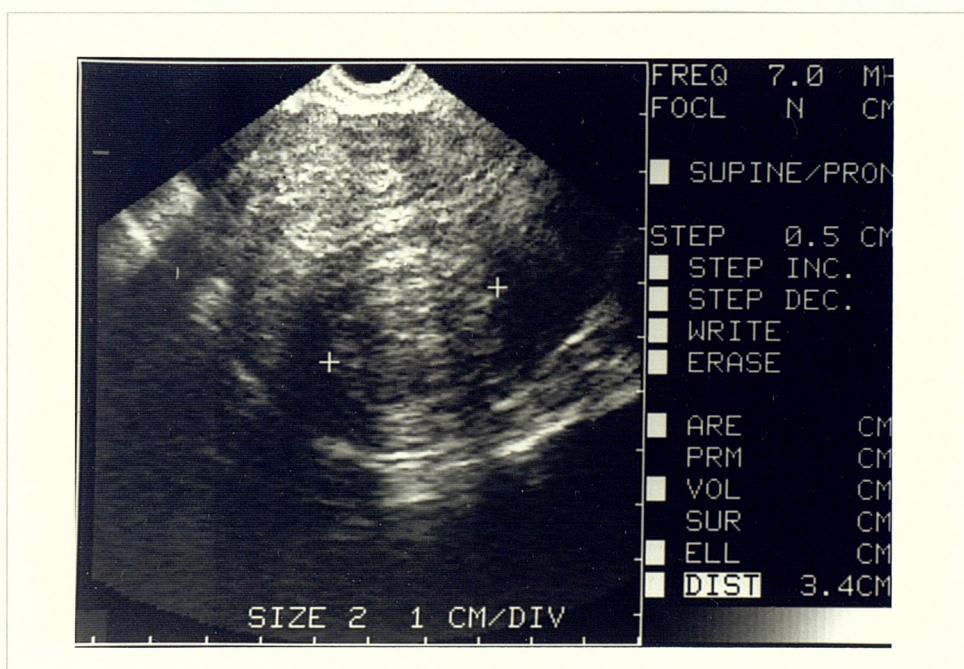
Transvaginal ultrasound of fibroid
